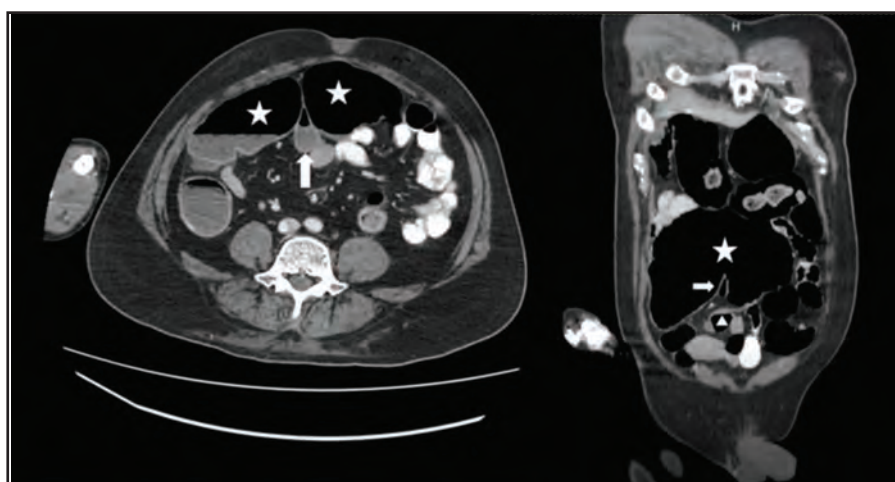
Axial and Coronal CT Abdomen showing anteromedially migrated dilated caecum (white star) with abnormally located terminal ileum (white arrow) and centrally located appendix (white arrow head).
